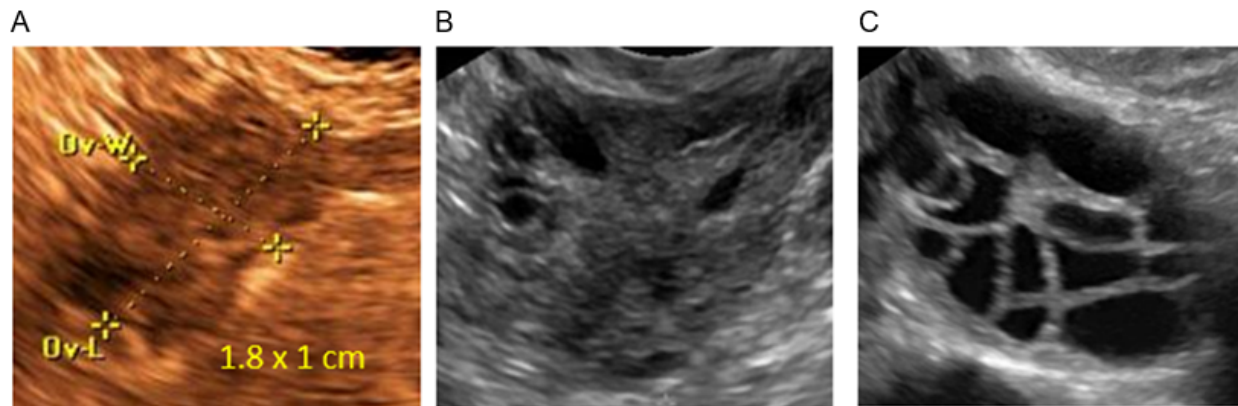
Ovarian sonographic imaging of women in their mid-30's. Figure 3A is from a woman with premature ovarian failure and there are no visualized antral follicles (the sonographically anechoic regions measuring approximately two to nine millimeters within the ovary). Figure 3B is from a woman with tubal factor infertility, and for whom seeing a few follicles within a single plane of the ovary would be normal. Figure 3C is from a woman with polycystic ovarian syndrome. Though her ovary is arguably more multicystic than polycystic (which would typically have follicles concentrated on the periphery of the ovary), she met the criteria for PCOS and her ovary is clearly distinct from those shown in 3A and 3B. Of note, all three ultimately conceived with their own oocytes, so it should be remembered that the absence of visualized antral follicles makes conception far less probable, but not impossible.
